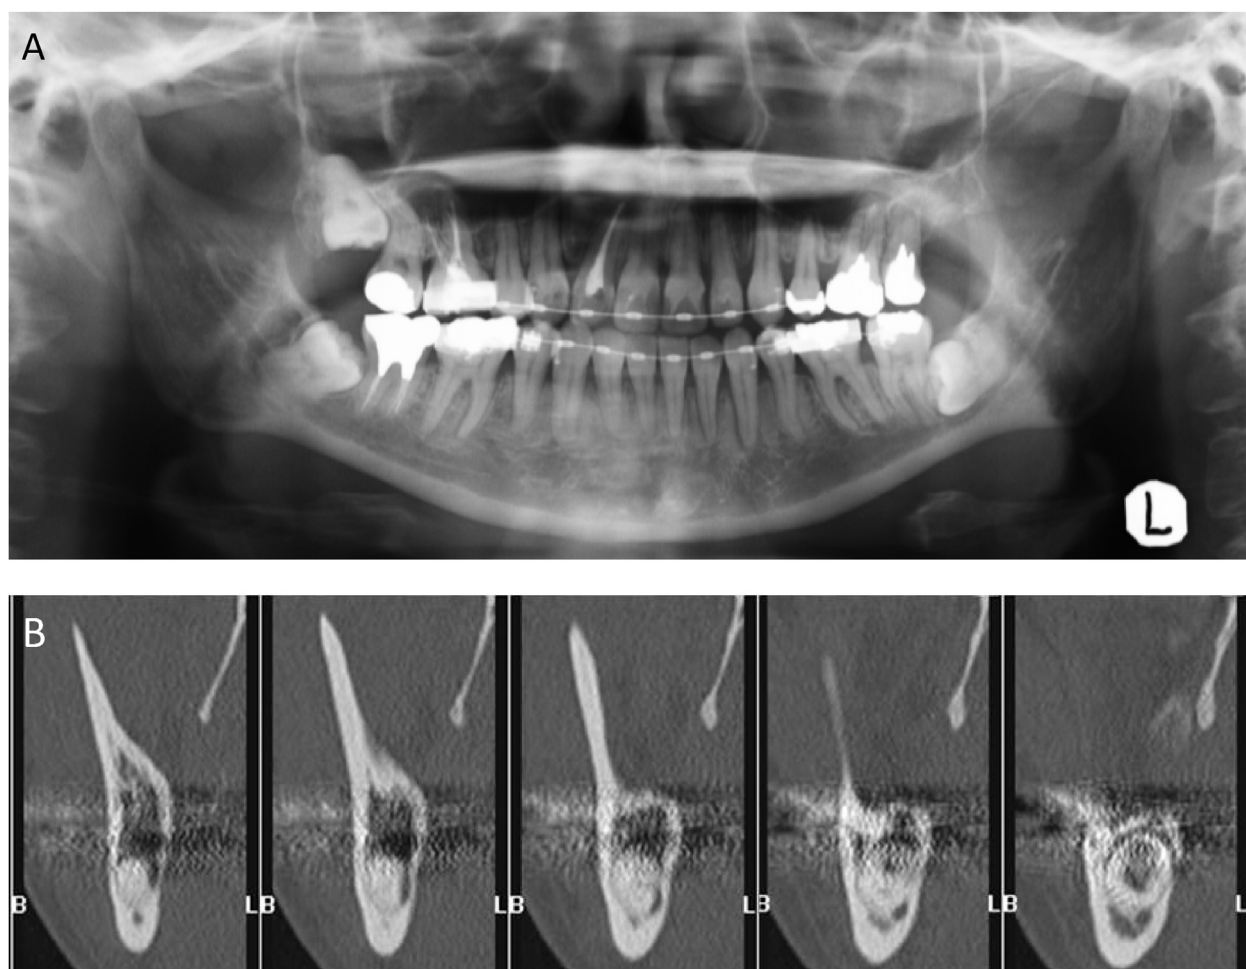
(A) Representative panoramic radiograph showing an overlap of the right lower third molar and the inferior alveolar canal (IAC). (B) Representative computed tomography images demonstrating the absence of cortication between the IAC and the lower third molar, the shape of the IAC, and the position of the IAC.
